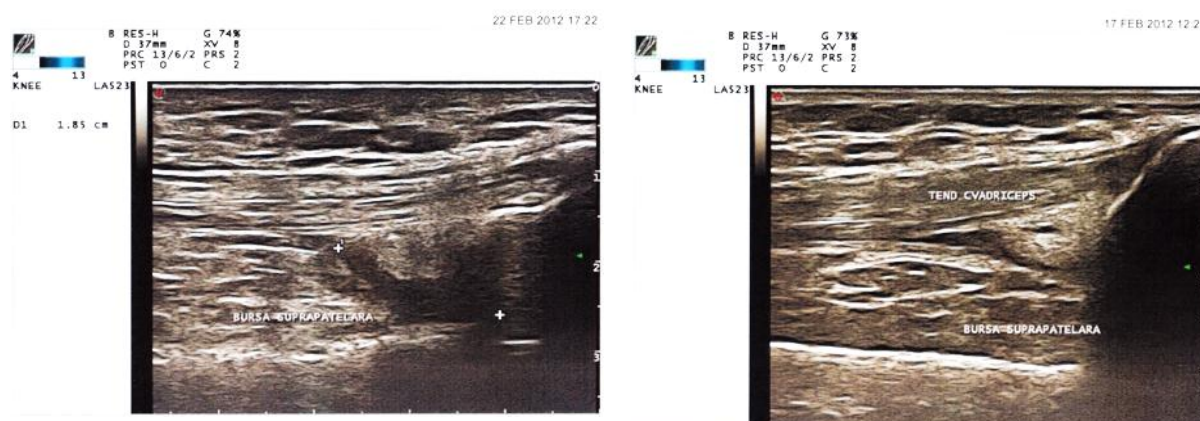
a, b. Ultrasonography of post-traumatic knee joint (2a- suprapatellar bursitis; 2b- quadriceps tendinitis) (authors' personal collection, having the patient's informed consent)
